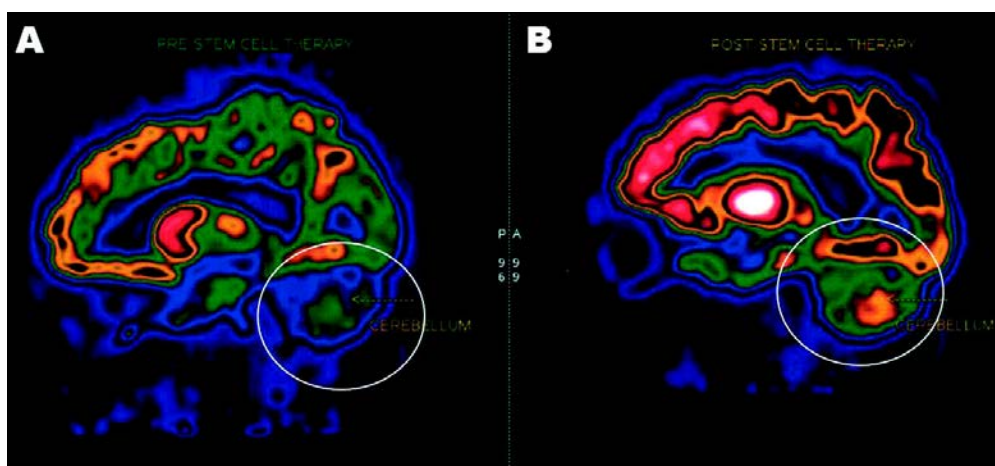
PET CT Scan showing improved metabolic activity which is indicated by increased orange area in the cerebellum after stem cell therapy as indicated by the circles.
